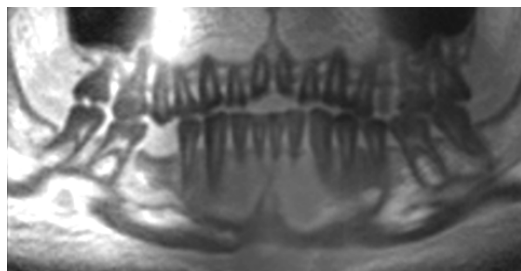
An in-vivo X-ray style curved slice along the jaw arc is shown. The corticalis and the spongiosa of the bones can be distinguished. The pulp of the teeth is seen at high signal and enamel on top of the teeth shows slightly darker than the dentin.
